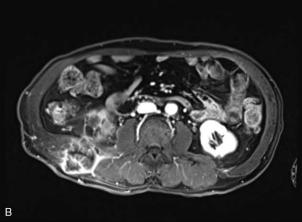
Magnetic resonance imaging (MRI) of the abdomen showing enhancement of the lesion. (A) T1 fat suppression coronal images show a 4.0×5.0 cm well-defined mass of the integumentary system near the right flank. (B) and (C) T1 fat suppression coronal and transverse images reveal multiple signals around the dermis and muscles connected to the right kidney. A lesion with parenchymal invasion measuring approximately 3.0 cm in diameter near the lower pole of the right kidney is shown.
